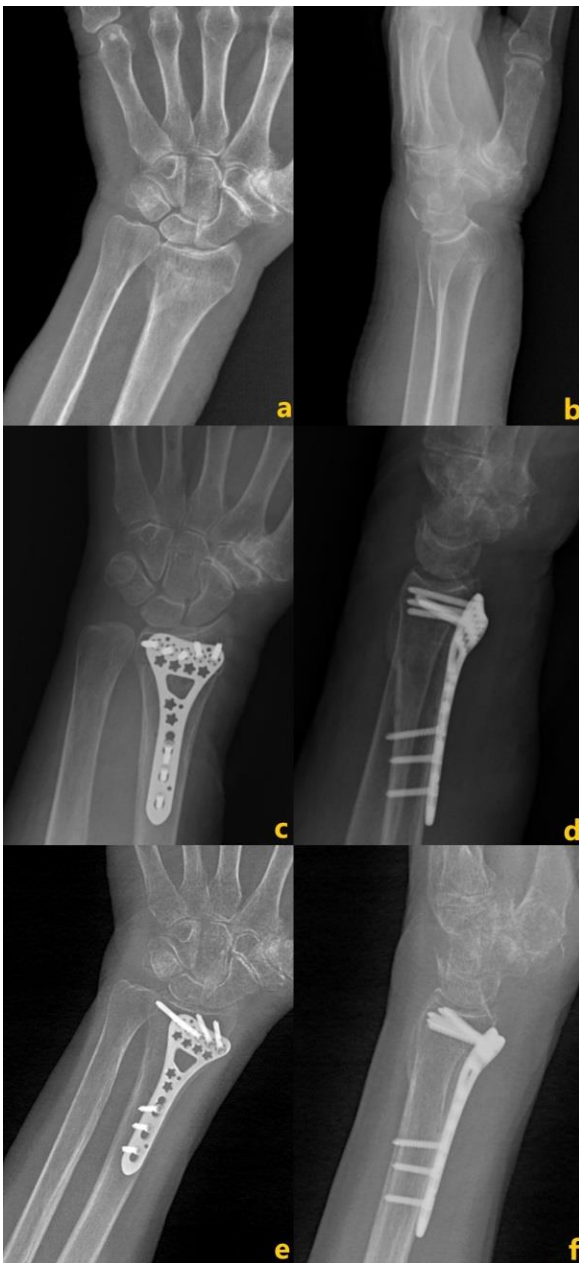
Anteroposterior (AP) (a) and lateral (b) radiographs of a 64-year-old male patient who presented to the emergency department after a simple fall showed a displaced distal radius fracture. In the immediate postoperative AP (c) and lateral (d) radiographs of the patient who underwent volar locking plate via open reduction and internal fixation, anatomical reduction was observed. In the AP (e) and lateral (f) radiographs of the patient taken 6 weeks after surgery, complete healing was achieved in the fracture line.
